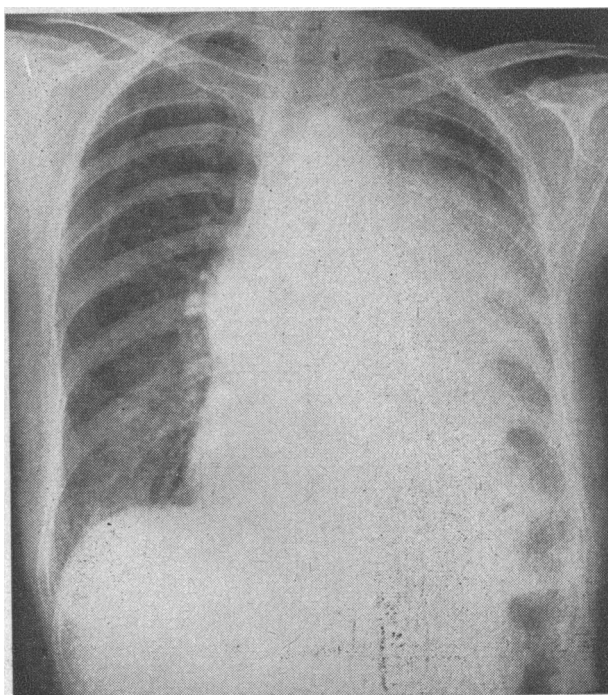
X-ray film taken on January 19, 1959.
